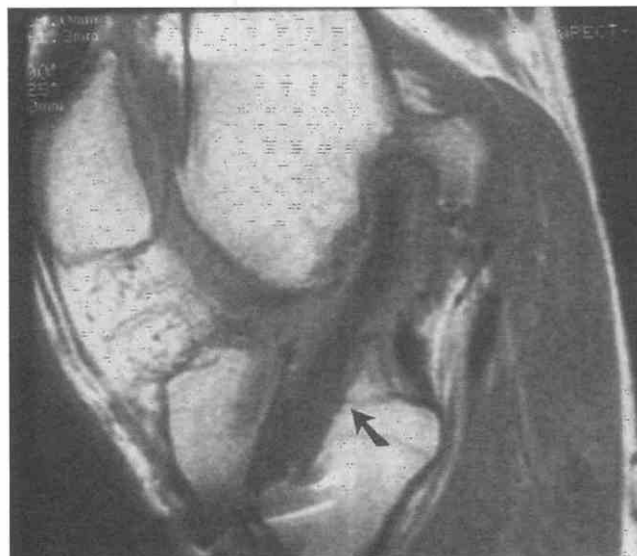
Anterior cruciate ligament (ACL) reconstruction. Sagittal T2-weighted image shows a normal-appearing ACL repair with patella tendon autograft (arrow). (Photograph courtesy of Dr. Padron, Madrid, Spain.)
